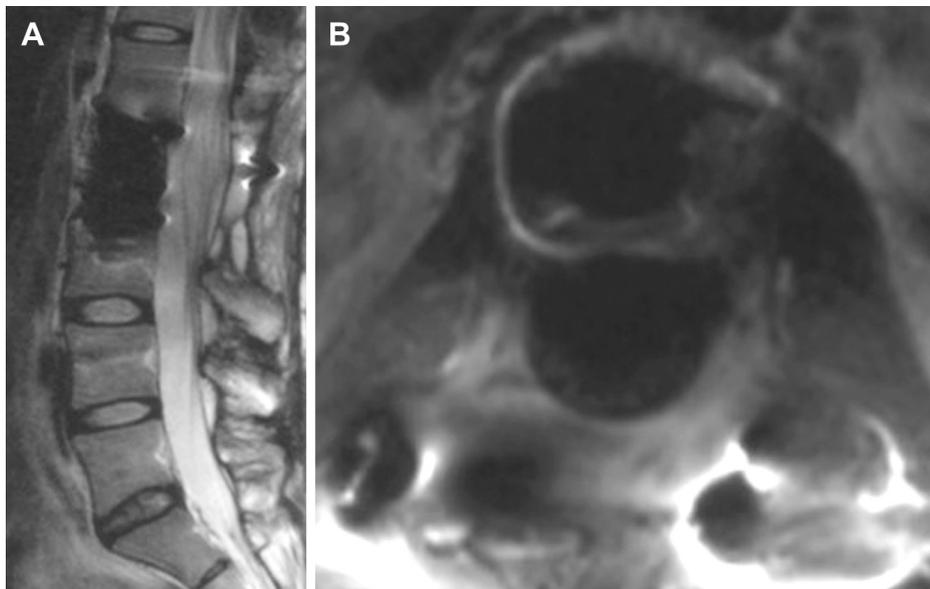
Magnetic resonance images 6 months postoperatively: (A) sagittal and (B) axial views.
